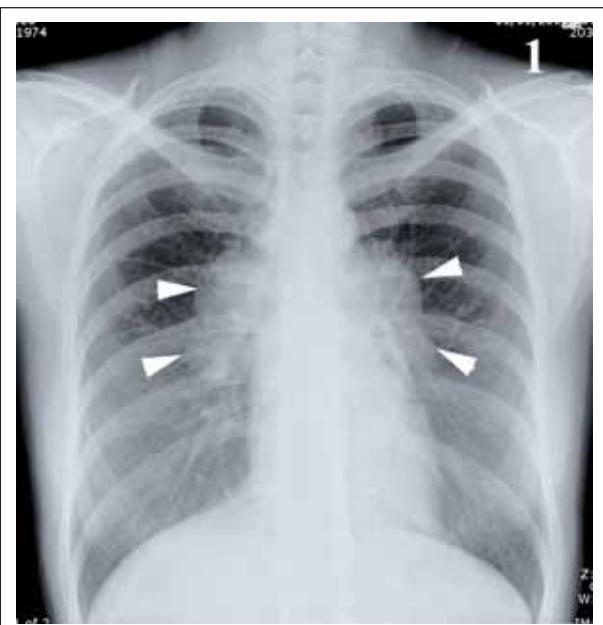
Chest radiograph shows symmetrical bilateral hilar lymph node enlargement.
